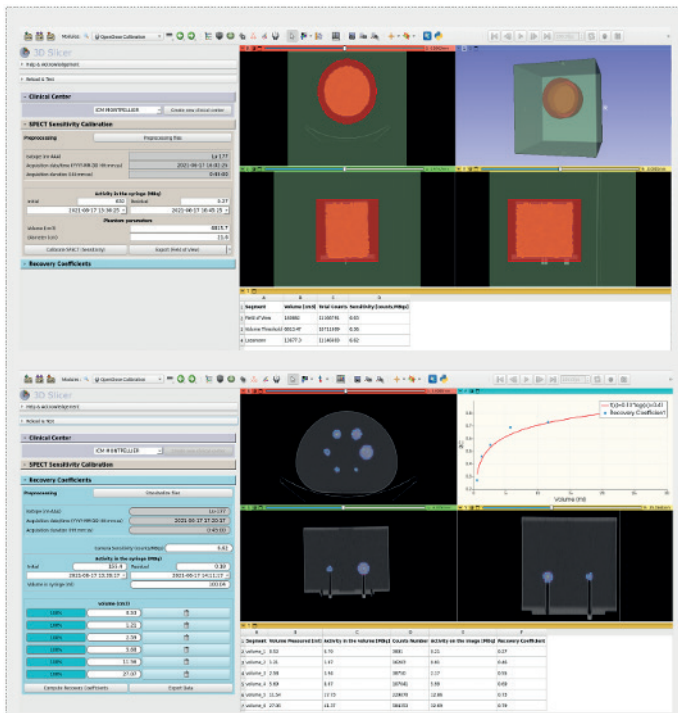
OD3D Calibration module includes SPECT sensitivity calibration and recovery coefficients determination.
